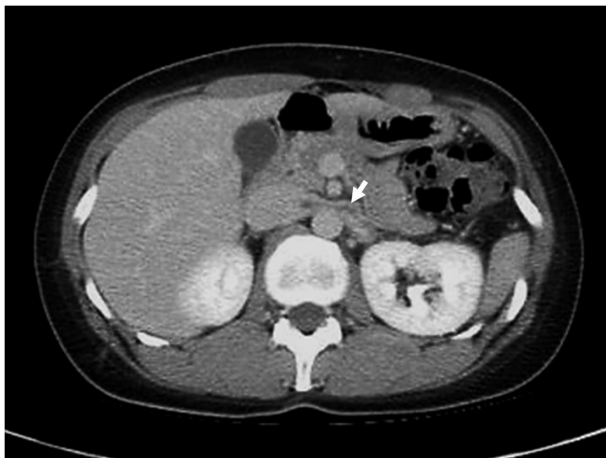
Repeat contrast-enhanced computed tomography scan 1 week postanticoagulation, showed a residual thrombus in the left renal vein.
